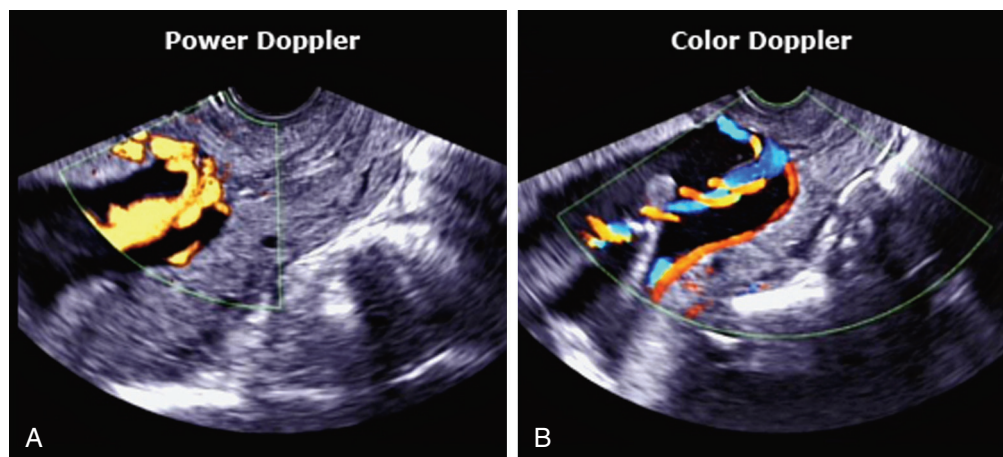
Transvaginal ultrasound images showing vasa previa and velamentous cord. The placenta is posterior with an anterior succenturiate lobe. (From Lockwood CJ, Russo-Steiglitz K. *Velamentous umbilical cord insertion and vasa previa*, www.uptodate.com, July 17, 2015.)
